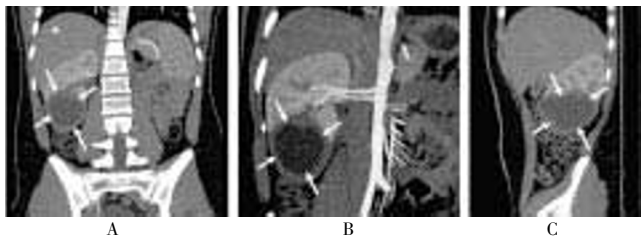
Computed tomography. (A) and (B) – Front view, (C) – Lateral view. The arrows indicate the hydatid cyst.
